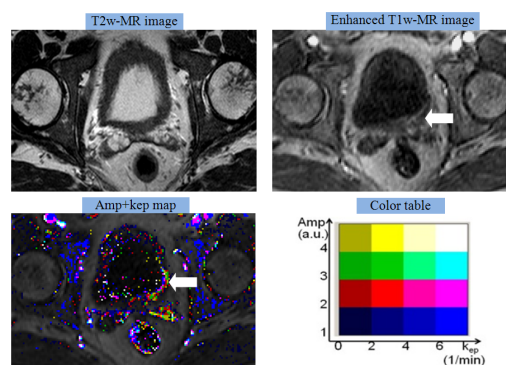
(a male patient, age = 47): The tumor residue indicated by arrows was isointense with the benign wall thickening on the T2w-MR image, but, identified on the enhanced T1w-MR image and the color Amp+kep map.
